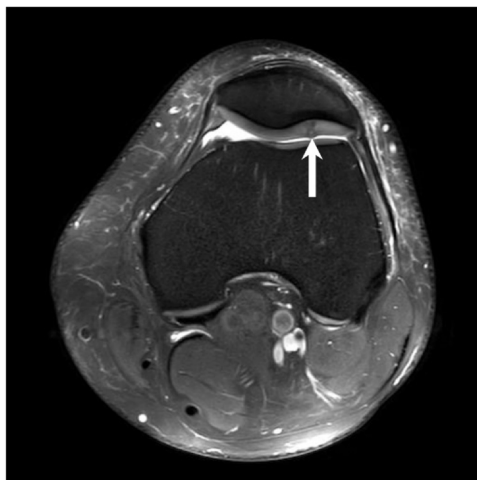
Elite baseball player presents with 2 weeks of anterior knee pain. Axial PD FS MR image of the knee demonstrates a chondral blister lesion with focal bulging of the superficial cartilage surface at the lateral patellar facet. Though such lesions may appear to be superficial, they extend to the level of the tidemark and can progress to unstable cartilage lesions over time. FS, fat saturation; MR, magnetic resonance; PD, proton density.
